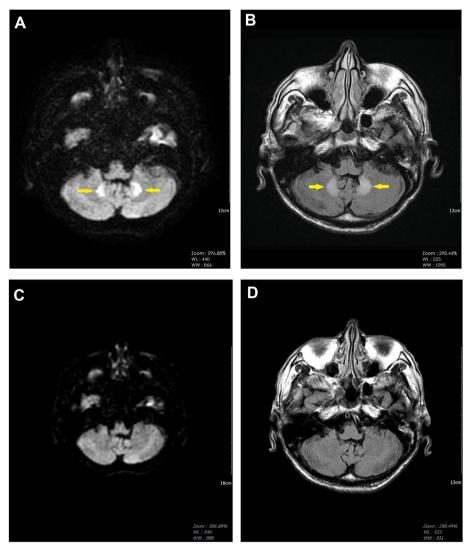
Brain magnetic resonance images of a 71-year-old man with recurrent falling (A, B) and at the 1-month follow-up after discontinuation of metronidazole (C, D). Axial diffusion-weighted imaging (Fig. 1A) and T2-weighted FLAIR (Fig. 1B) sequences showed symmetric hyperintensities (yellow arrowheads) in bilateral cerebellar dentate nuclei. Near-complete recovery from hyperintense lesions was discovered in bilateral cerebellar dentate nuclei in both series (Fig. 1C and D) following 1-month cessation of oral metronidazole use.
